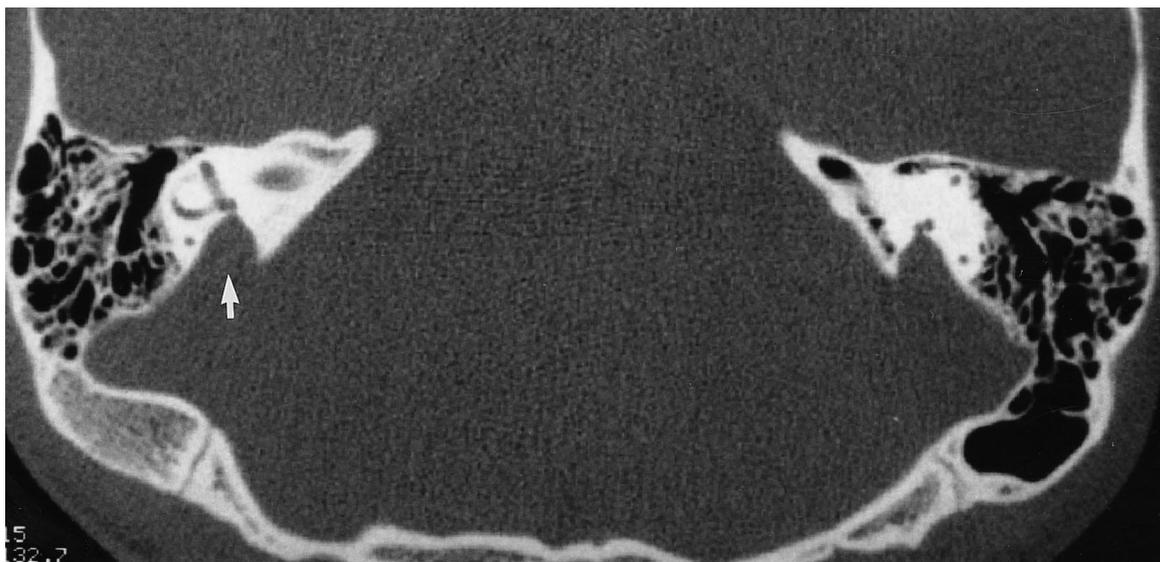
Axial CT section of the petrous temporal bones at the level of the lateral semicircular canal and internal auditory meatus showing enlarged vestibular aqueduct (arrow).
